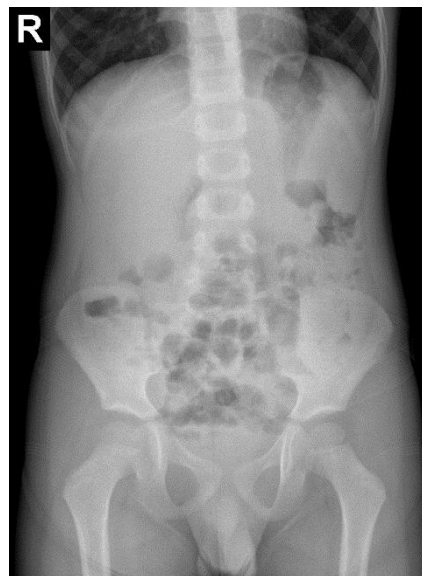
X-ray of the abdomen.
